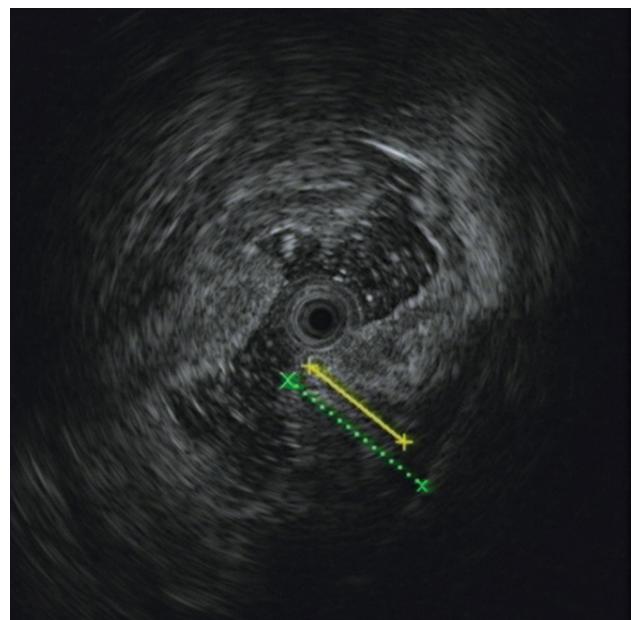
Endoscopic ultrasonography showed the gastric body wall was significantly thicker, with the thickest point measuring 1.63 cm, and disappearance of normal hierarchy.
